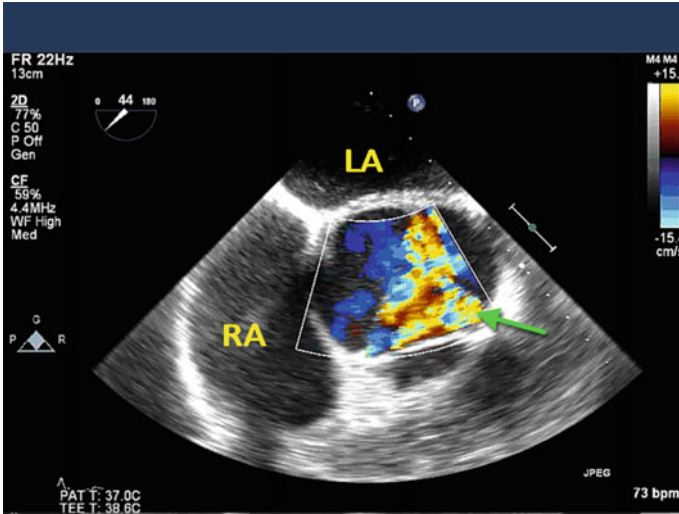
Midesophageal aortic valve short axis view with color flow Doppler in a patient with an ascending aortic aneurysm. The *green arrow* indicates the significant aortic insufficiency from the associated dilated annulus and ascending aortic aneurysm (LA left atrium; RA right atrium)
